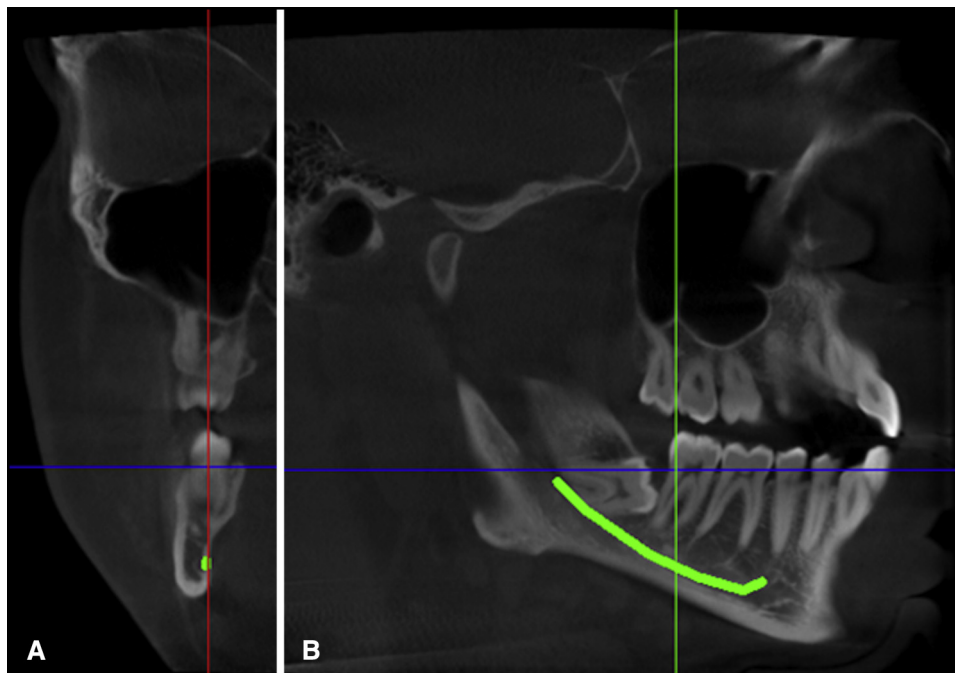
Three-dimensional reconstructions of CBCT image showing the traced nerve canal in different views: A, coronal slice; B, sagittal slice.
